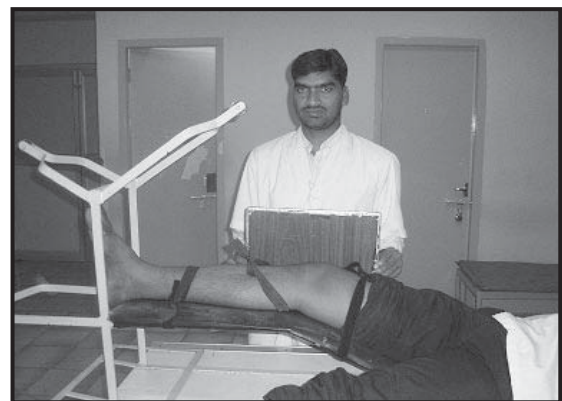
Position of the patient and limb for lateral X-ray of knee joint without weight.
